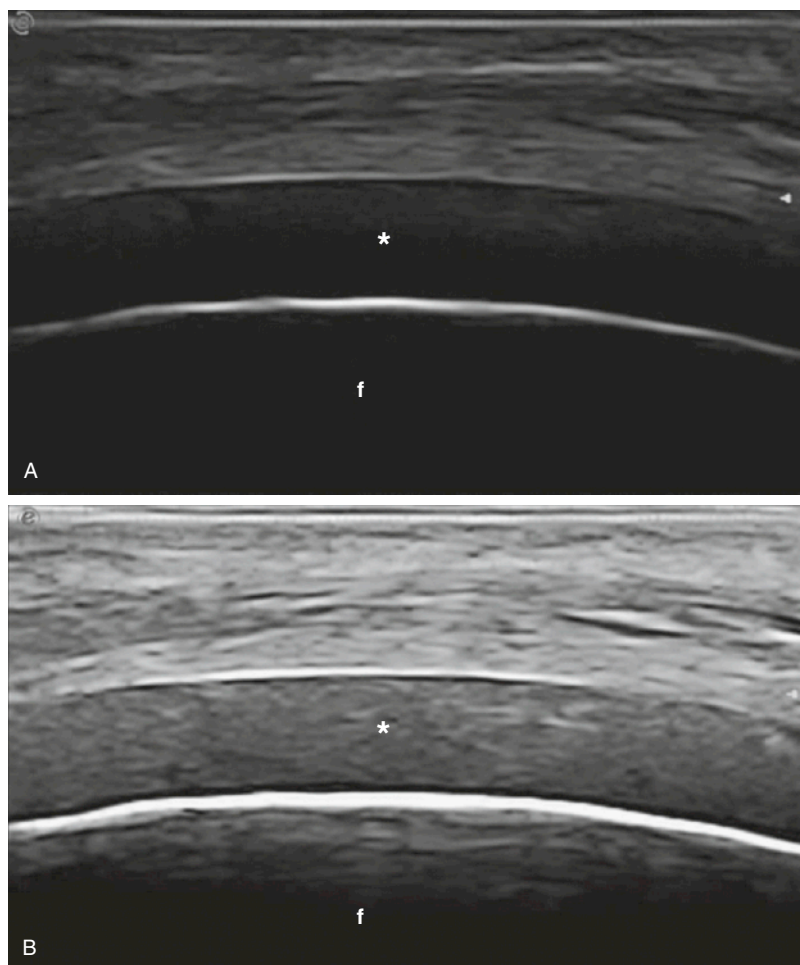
NORMAL KNEE. Longitudinal anterior view shows the knee joint in maximal flexion. Sonographic images were acquired using different levels of gain: low (A) and high (B). Cartilage echotexture is homogeneous at different levels of gain (*stars*). f, lateral femoral condyle.
